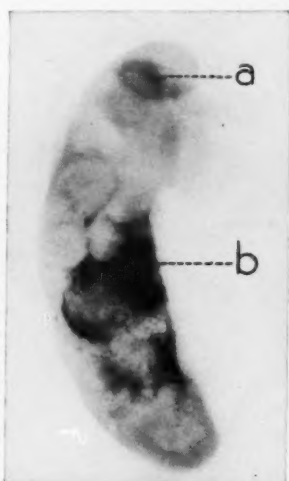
Case 1: Roentgenogram of gallbladder containing multiple cholesterol-pigment stones with one stone in cystic duct (a) showing calcium carbonate shadow (b) in lumen.
